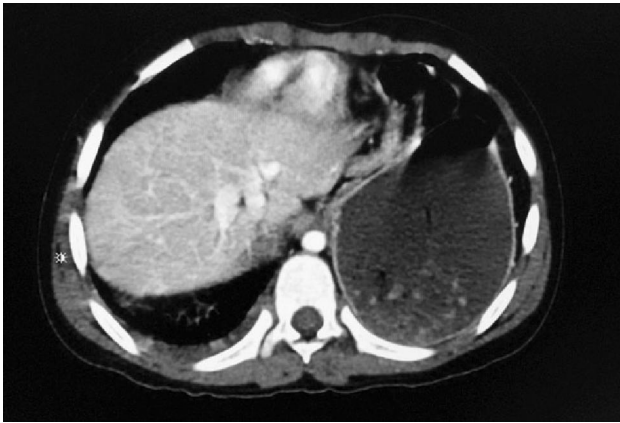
CT Scan chest with contrast showing intrathoracic herniation of stomach through left sided traumatic rupture of the diaphragm mimicking hydropneumothorax.
